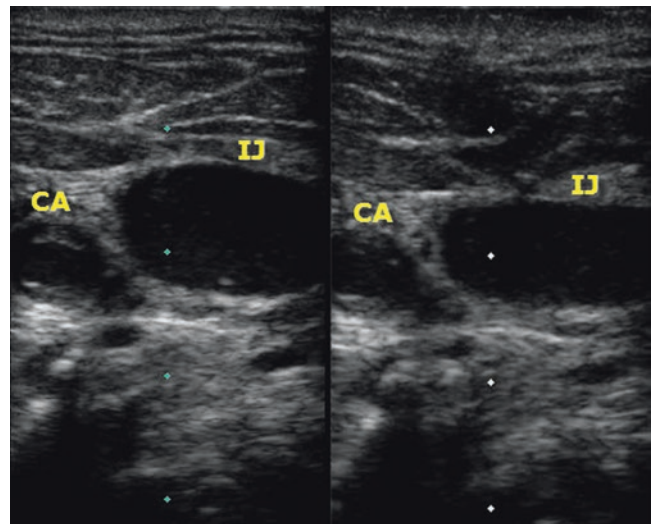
Ultrasound images of the neck vessels demonstrating a transversal view of the carotid artery and the internal jugular vein. Gentle pressure with the probe over the vessels is used for confirmation of the anatomy as it results in compression of the vein but not the artery (Image on the left: no compression. Image on the right: with compression). CA carotid artery, IJ internal jugular vein
